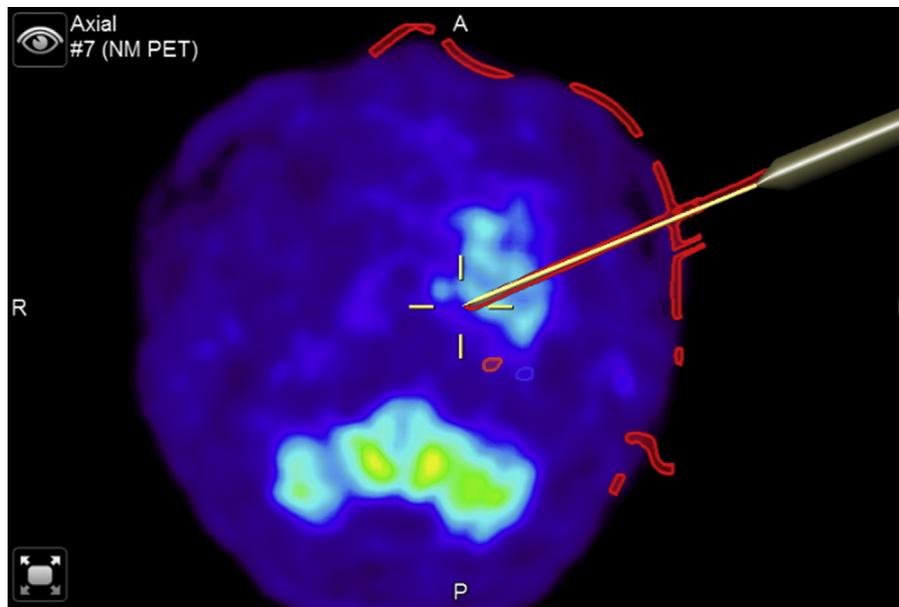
Needle tip location verified by navigation system using positron emission tomography with computed tomography.
